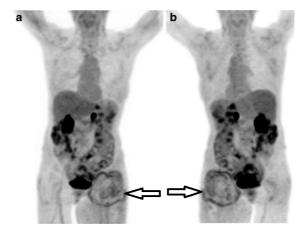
[18 F]FDG PET/CT showing in (a) anterior and (b) posterior maximum intensity projection views a large irregular heterogenous pseudotumor caused by ARMD at the left hip with a maximum diameter of 16 cm with a maximum standardized uptake value (SUV_{max}) of 3.4 (Makis et al. 2011).
